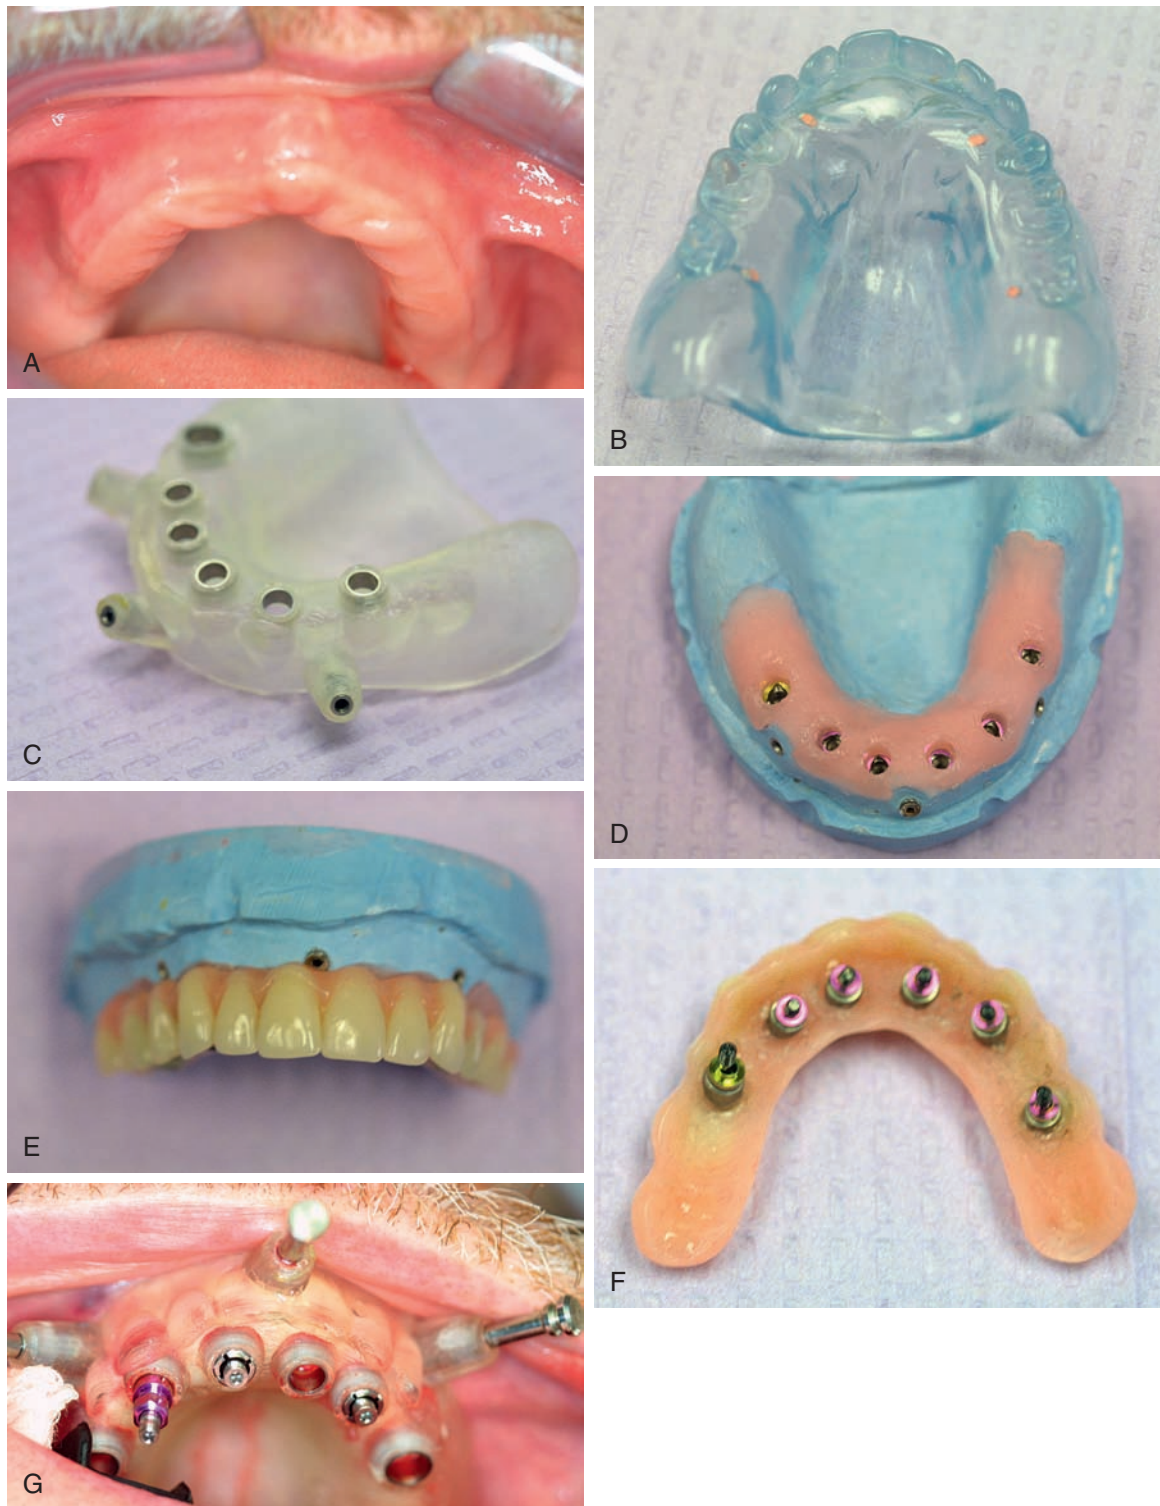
A, Clinical evaluation of maxillary ridge. B, Duplicate denture with radiographic markers for cone beam scan. C, CAD-generated surgical guide. D, Lab-fabricated model. E, Presurgical fabrication of a fixed temporary restoration. F, Insertion of guided abutments into fixed temporary restoration. G, Stabilized and secured surgical guide for implant insertion.
